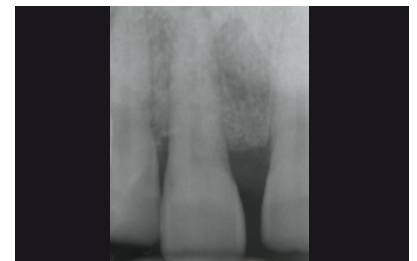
Post-operative radiograph, showing the intrabony defect filled by the implanted material.
